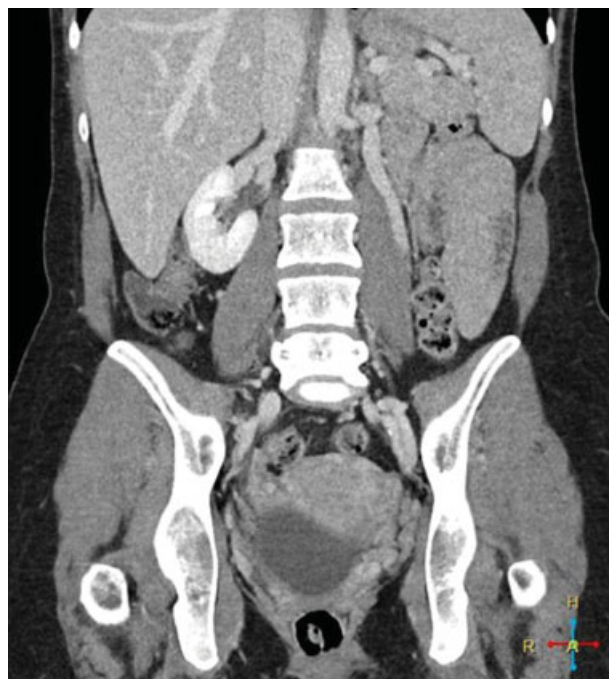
Coronal CT venogram with dilated left gonadal vein.
